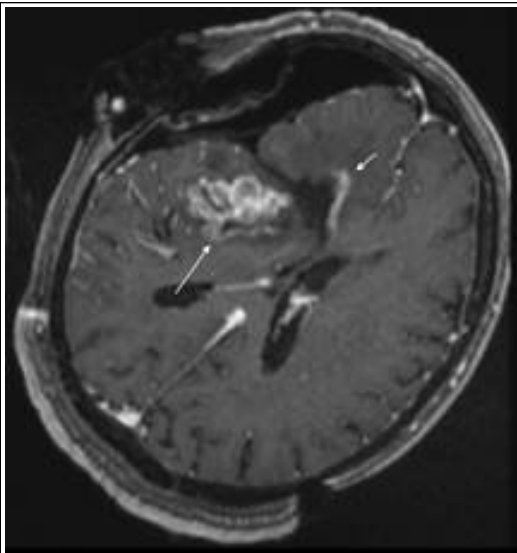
T1 contrasted intra-operative MRI after initial debulking that was felt to have been gross total resection. Medial and lateral portions resected but residual tumor anterior and posterior (arrows).
